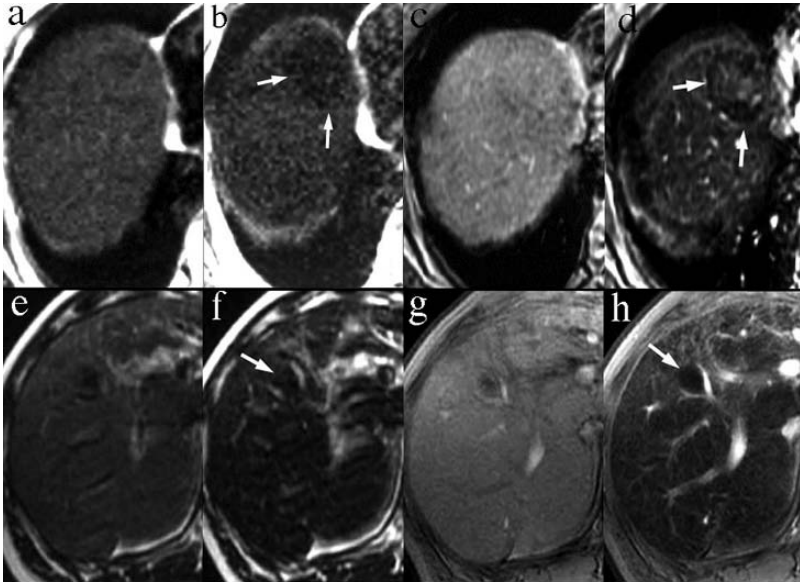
Differentiation between DN and well-differentiated HCC by SPIO-enhanced MR imaging. Both well-differentiated HCC in a 64-year-old female (a) and DN in a 55-year-old male (e) exhibit homogeneous signal decrease on T_2 W-FSE after SPIO administration (b, f; arrows). Differentiation between HCC and DN is therefore difficult with this sequence. On T_2^* W-GRE, well-differentiated HCC exhibits heterogeneous signal decrease (d, arrow), but DN exhibits homogeneous signal decrease (h, arrow). T_2^* W-GRE thus aids differentiation between HCC and DN.
